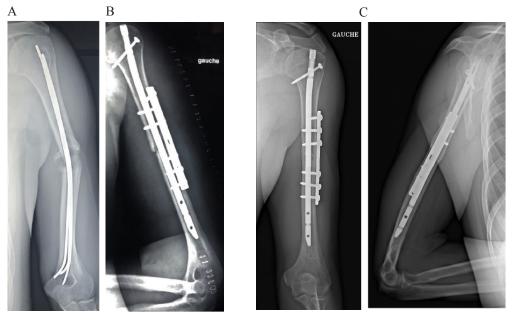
A 23-year-old patient with a closed fracture of the middle part of the left humeral shaft from direct trauma. After an initial surgical treatment by fasciculated pinning, he presented at 12 months with an oligotrophic aseptic non-union of the middle part of the left humeral shaft. A) Preoperative X-rays, B) Immediate postoperative X-rays, C) X-rays at 24 weeks post-op. RUST=12.
